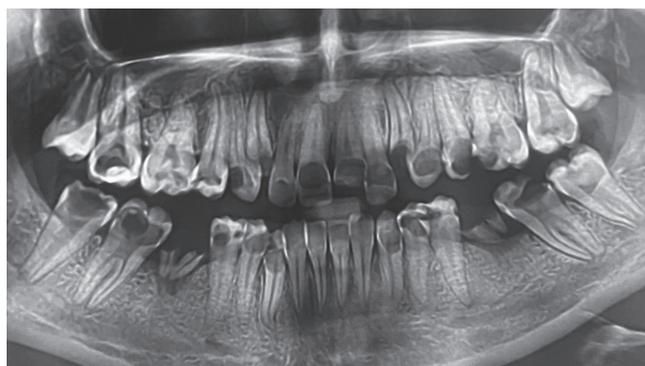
O.M., 19 years old - radiological aspect, panoramic radiography.
